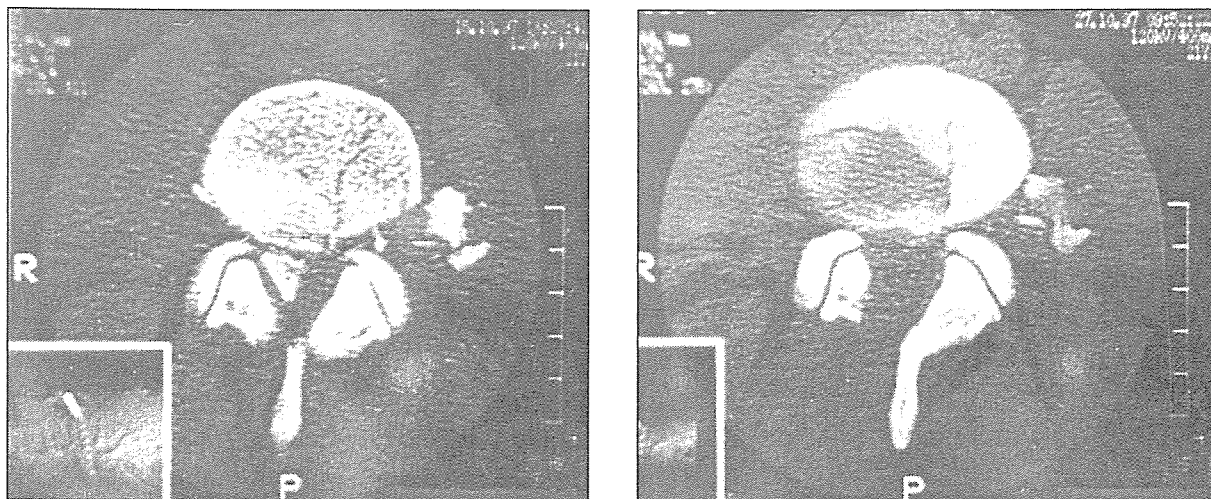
Preoperative (a) and postoperative (b) CT images of the second case. Radiographic appearance of the fracture can be considered as biomechanically stable.
